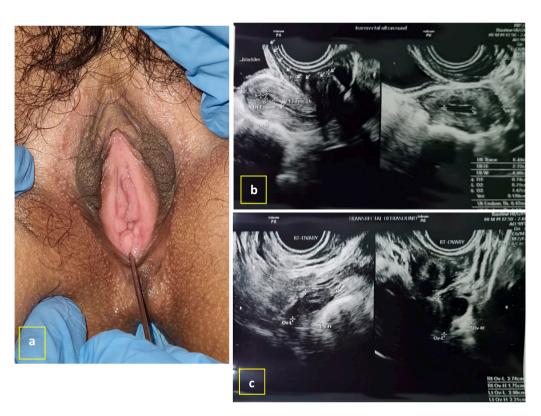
First case's 10 months after surgery evaluation. A. sound could be inserted with no resistance. b. Ultrasound found no haematometra. c. Ultrasound found normal ovaries and no haematosalphing.
